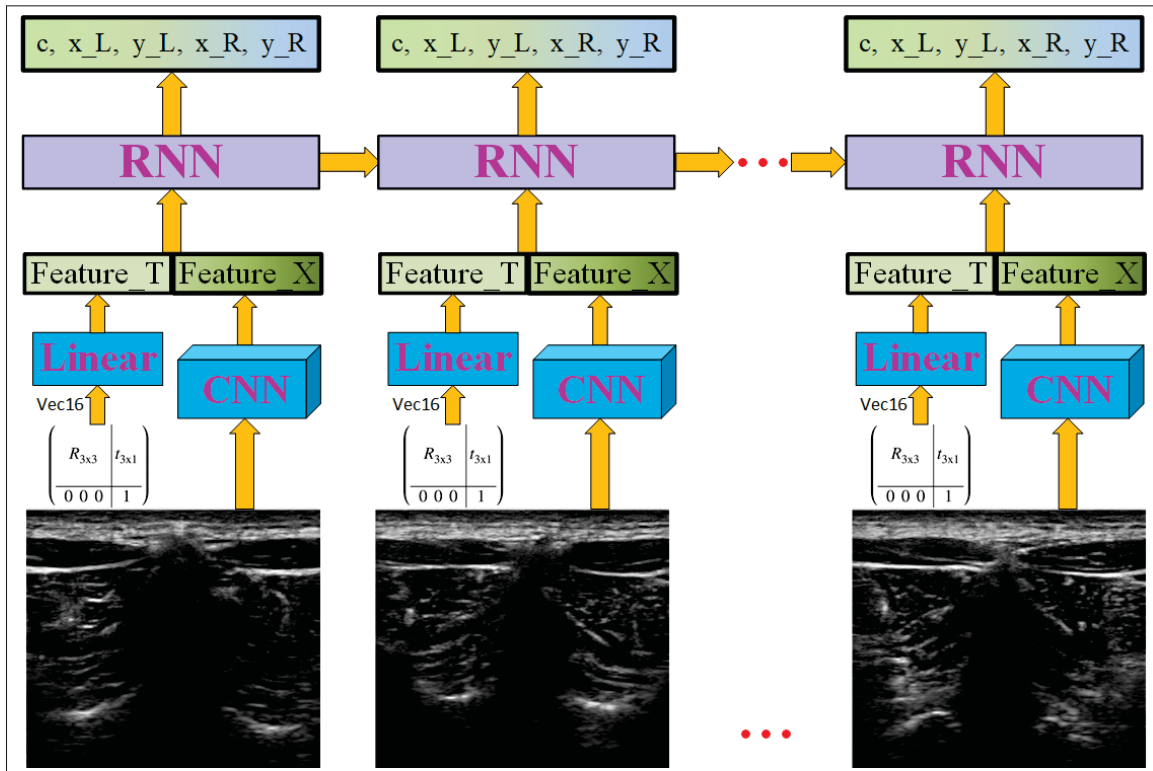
SL-RCN for 3D lamina curve extraction from ultrasound
